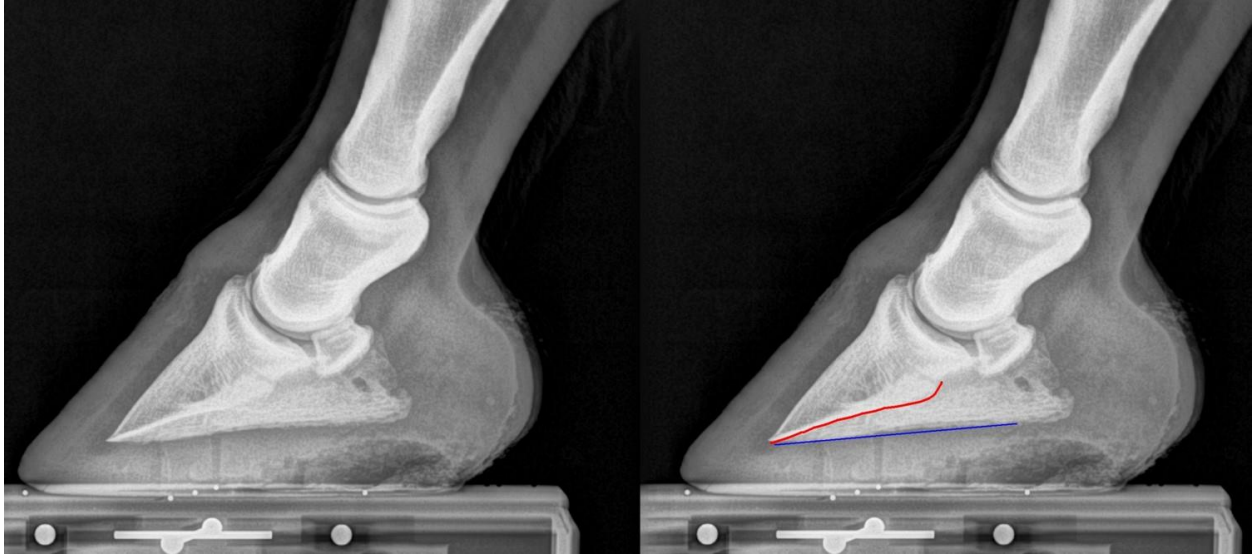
Left and right images are the same, but on the right-hand image I have indicated (in red) the curve that I am calling the “palmar curve”. This curve is on the border of a high-density portion of the bone that images bright white in a radiograph due to its density. It is an area of the P3 bone which must be strong and dense since the deep digital flexor tendon (DDFT) attaches near this area, and imparts large forces on the bone. The blue line is drawn at the distal border of the pedal bone, and is the line used to measure palmar angle relative to the ground. Roughly speaking, the space between the red curve and the blue curve tell us something about the amount of concavity of the palmar surface of the pedal bone.
